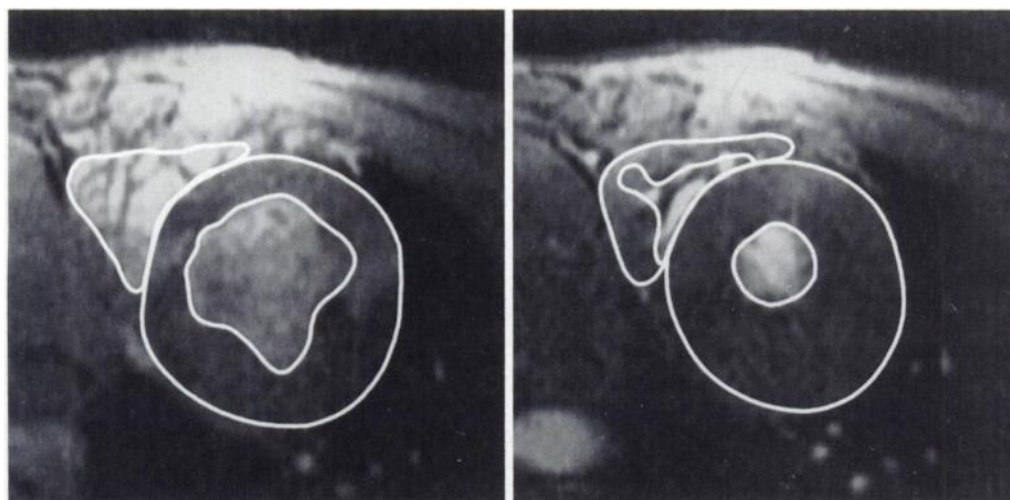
Short-axis gradient-echo breath-hold MR images of the left ventricle. Midventricular slices at (left) end-diastole and (right) end-systole. (Lower right contour) Contours for the left and (upper left contour) right ventricles are superimposed on these images.
